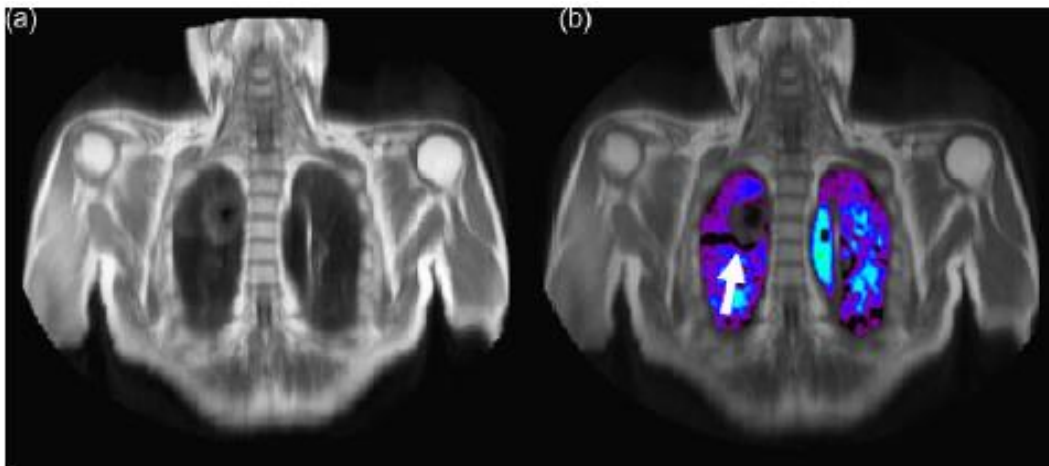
A 68-year-old male with pulmonary emphysema and lung cancer is depicted above. Figure (a) shows the MRI lung image which was captured by a T1 weighted IR-HASTE image and shows the tumour in the right side of the lung. Figure (b) is the relative map of the OE-MRI. The pulmonary parenchyma, with the exception of lung tumour (arrow); a heterogeneous and poor relative enhancement is shown owing to lung emphysema (Ohno and Hatabu, 2007).
